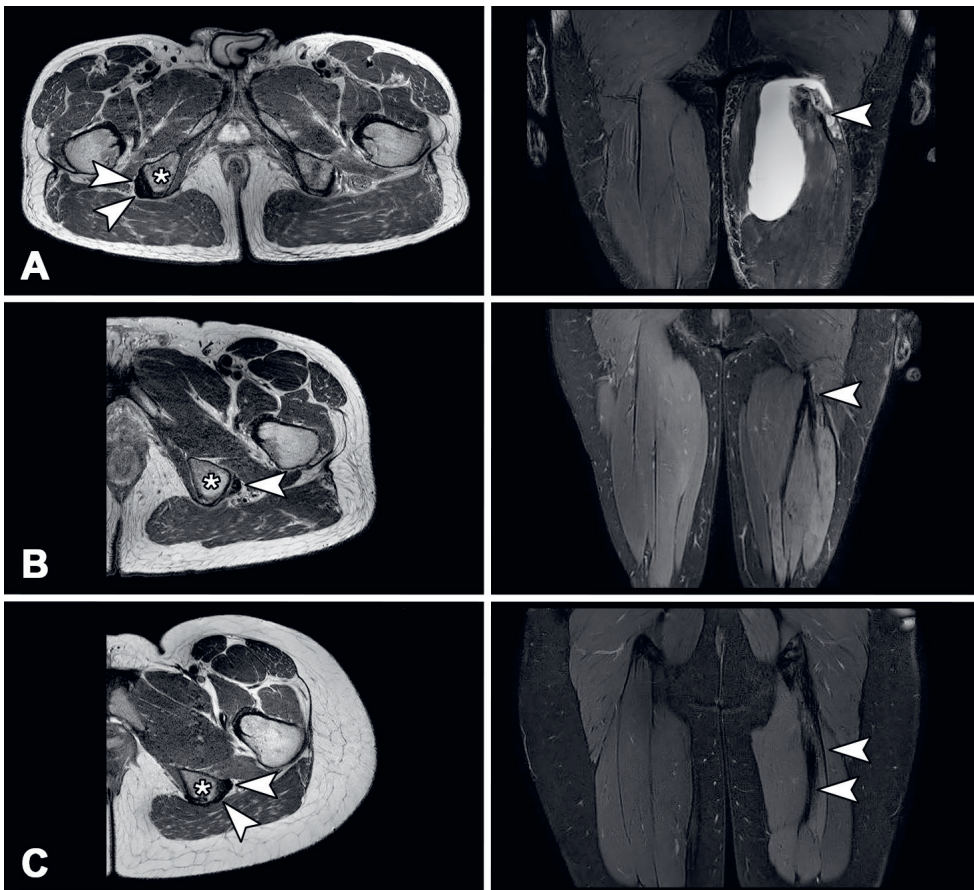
MRI assessment of proximal continuity following left-sided injuries. (A) No continuity. The axial image demonstrates both the conjoint (CT) and semimembranosus (SM) tendon (arrows) attached to the ischial tuberosity (asterisk) on the right but no tendons attaching on the left. The coronal image demonstrates discontinuity with the (hypointense) CT stump (arrow) in a haematoma indicating acute injury. (B) Continuity by a shared tendon at follow-up. The axial image shows a single attached neotendon (arrow) on the ischial tuberosity (asterisk). The coronal image demonstrates merging of both the CT and SM tendons (arrow) into a joint neotendon that courses proximally. (C) Continuity by separate tendons (arrows) on the ischial tuberosity (asterisk) at follow-up.
